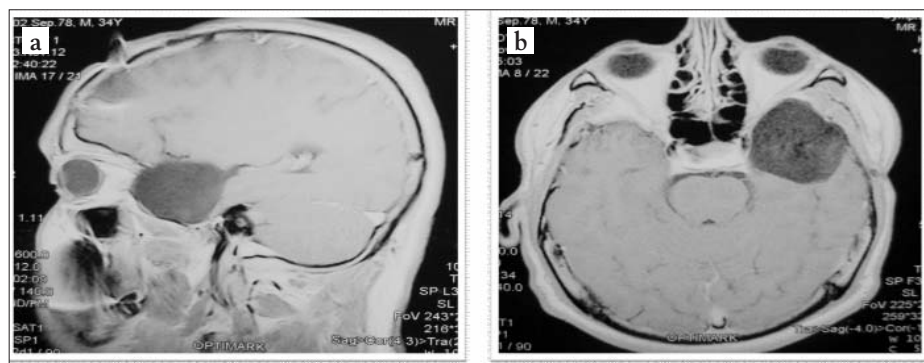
(a,b) MRI aspect in a patient with left temporal low grade glioma
